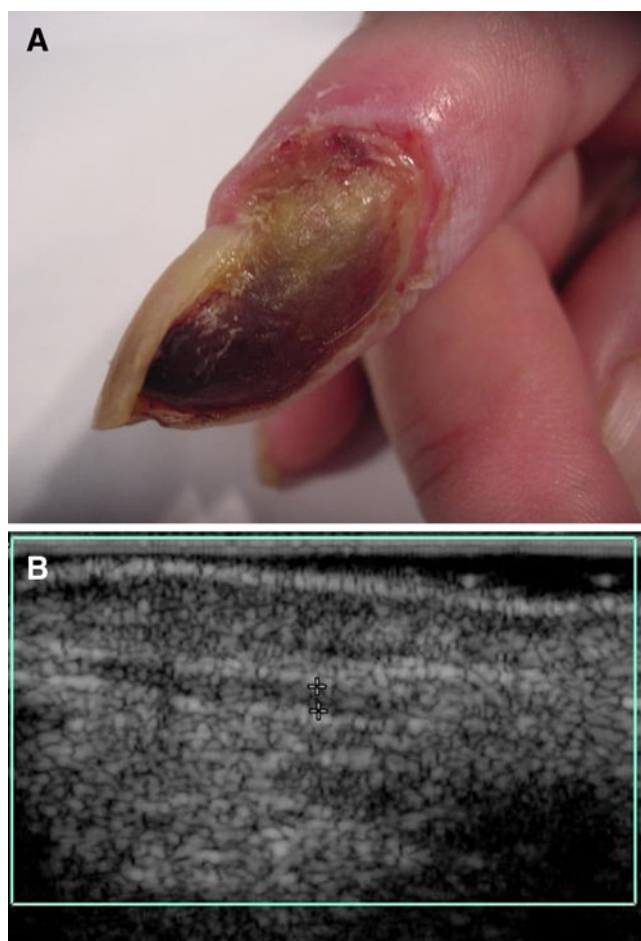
(A, B) Dorsal digital artery thrombosis in systemic lupus. A Clinical lesion. B Color Doppler ultrasound (longitudinal view) of the right index finger shows hypoechoic thrombotic material filling the lumen of the digital artery (between markers) without detectable blood flow
